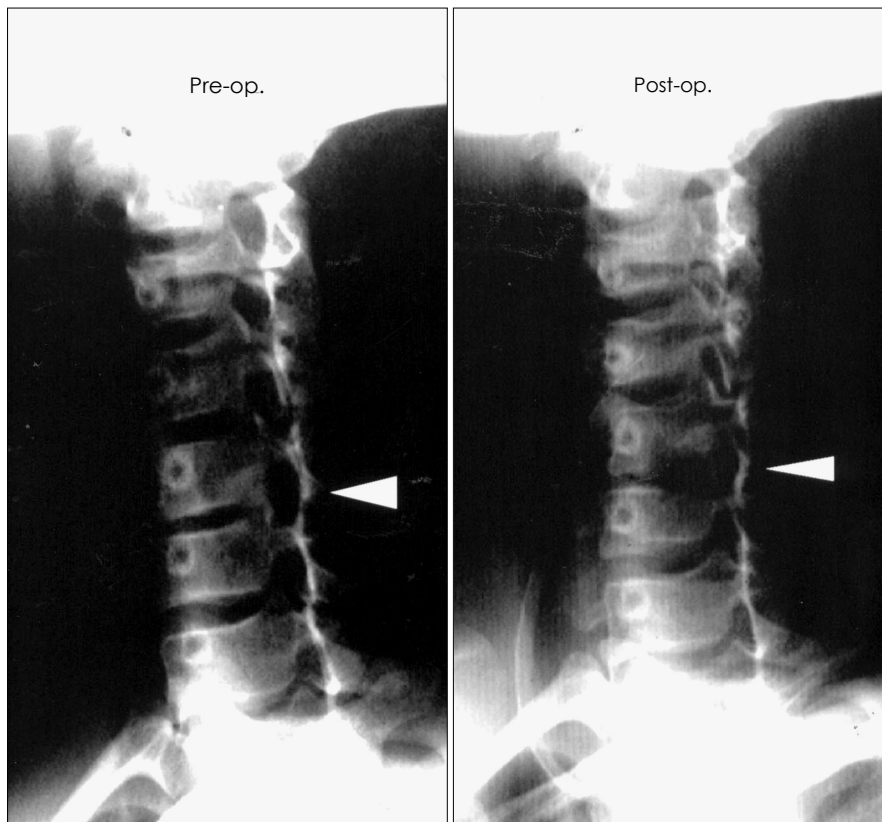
Pre-operative and post-operative(after 2 years) C-spine plain X-ray films demonstrating the preservation of disc space height and curvature.
